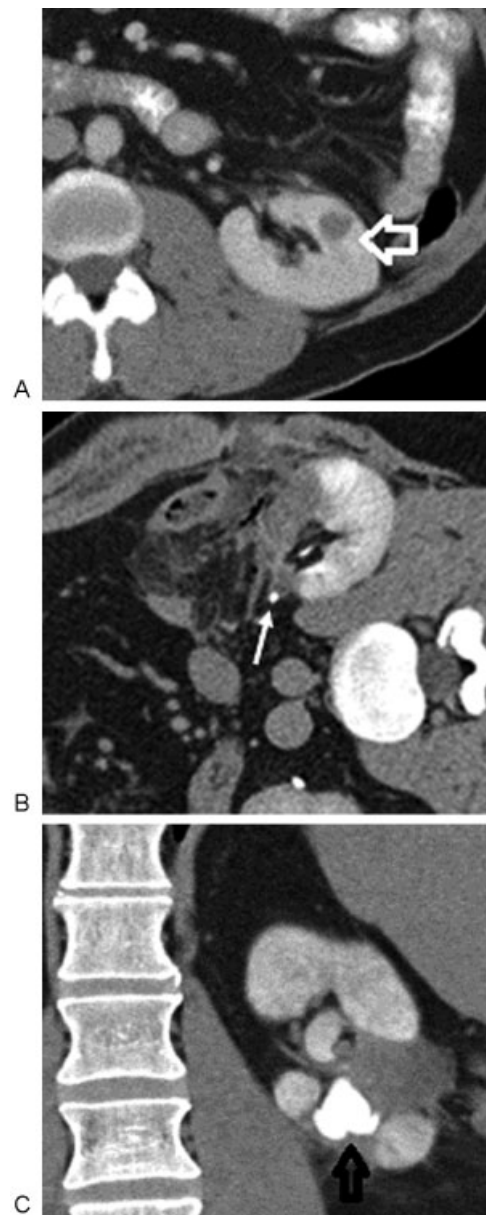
UPJ stricture following renal RFA. (A) Contrast-enhanced CT shows a 1.5-cm mass in the left mid kidney (arrow) of a 46-year-old man. Percutaneous RFA was proposed due to significant medical comorbidities and history of left partial nephrectomy for RCC. (B) Contrast-enhanced CT immediately following RFA shows the ablation zone encompassing the proximal ureter at the UPJ (arrow). (C) Coronal delayed contrast-enhanced CT 3 months later shows a dilated left intrarenal collecting system (arrow) due to UPJ stricture. This kidney eventually became atrophic and nonfunctional. CT, computed tomography; RCC, renal cell carcinoma; RFA, radiofrequency ablation; UPJ, Ureteropelvic junction.
